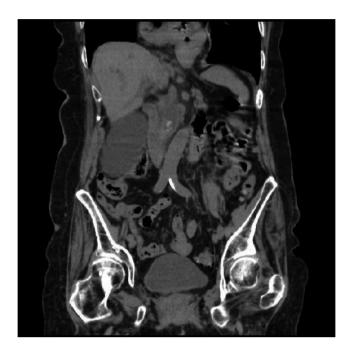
Abdominal computed tomography scan showing choledocholithiasis (8 mm in diameter).
